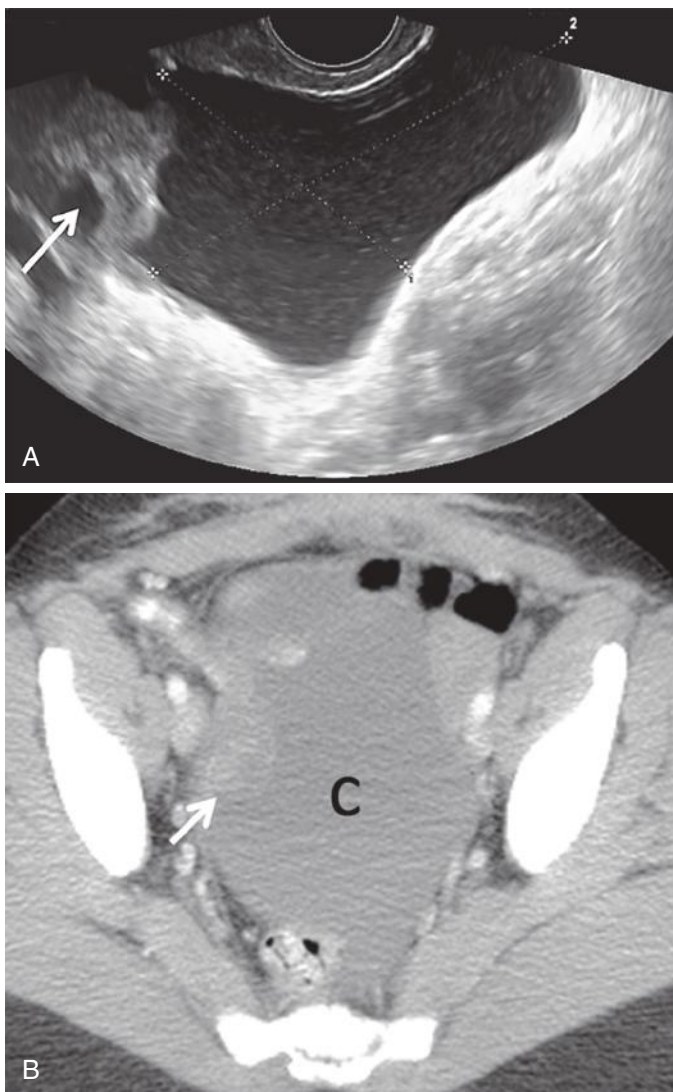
Peritoneal inclusion cyst. A, The right ovary (*arrow*) is noted along the superior wall of the cyst (*calipers*). Low-level echoes are present in the cyst fluid. B, Contrast-enhanced axial computed tomography shows the right ovary (*arrow*) along the cyst wall. The shape of the cyst (*c*) conforms to adjacent pelvic structures. The patient had previously undergone hysterectomy for leiomyomas.
